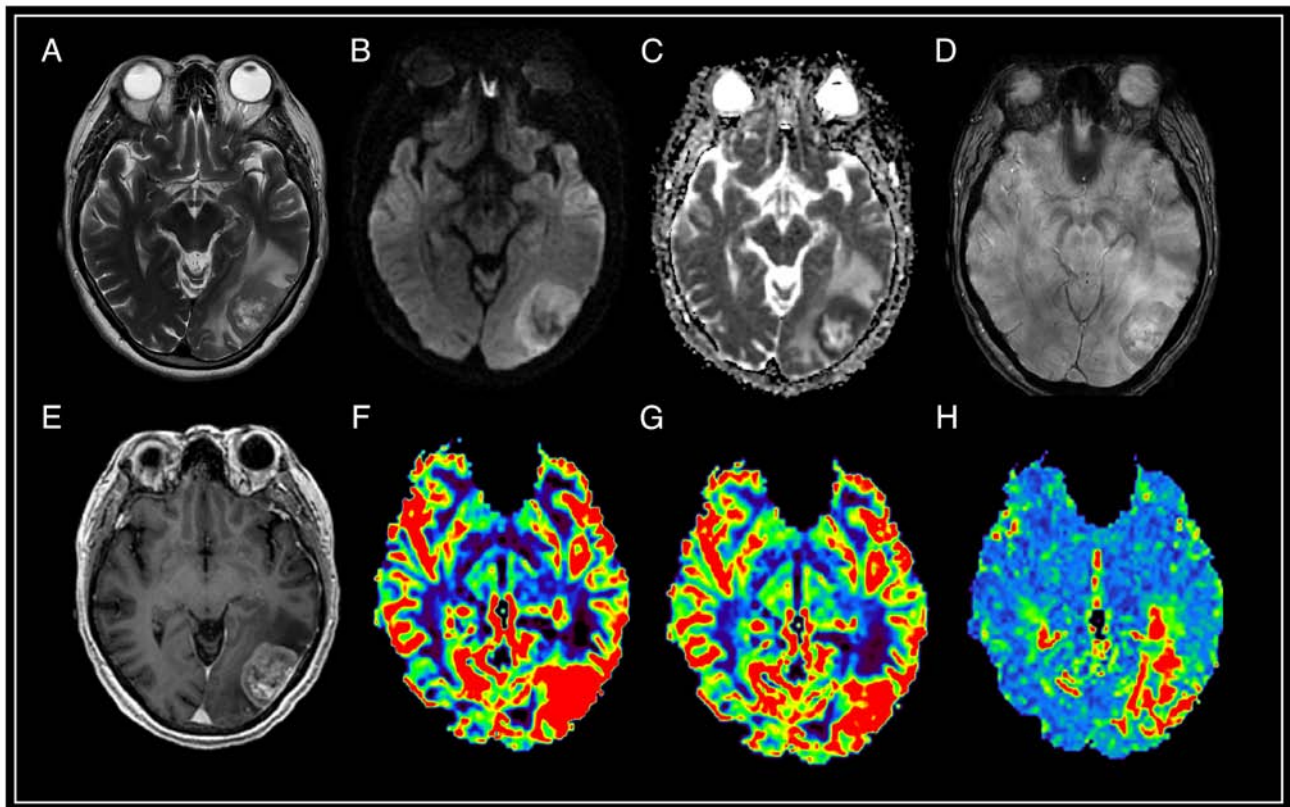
Brain magnetic resonance imaging with solitary intracranial dural metastasis of prostate adenocarcinoma. In the occipital region of the left hemisphere, an extracerebral formation is visible with heterogeneous contrast enhancement, and restriction of diffusion, surrounded by a pronounced zone of edema. SWAN indicates the presence of point artifacts of magnetic susceptibility due to hemorrhages and intratumoral vascular shunts. According to the results of MRI perfusion, high values of relative cerebral blood volume (rCBV) and relative cerebral blood flow (rCBF) in the tumor structure are determined. The mean transit time (MTT) indicator is extended. (A) T2-WI; (B and C) DWI and ADC; (D) SWAN; (E) T1-WI with contrast; (F) CBV; (G) CBF; and (H) MTT. SWAN, susceptibility-weighted angiography; T1-WI, T1-weighted image; T2-WI, T2-weighted image; DWI, diffusion-weighted imaging; ADC, apparent diffusion coefficient; CBV, cerebral blood volume; CBF, cerebral blood flow; r, relative; MTT, mean transit time.
